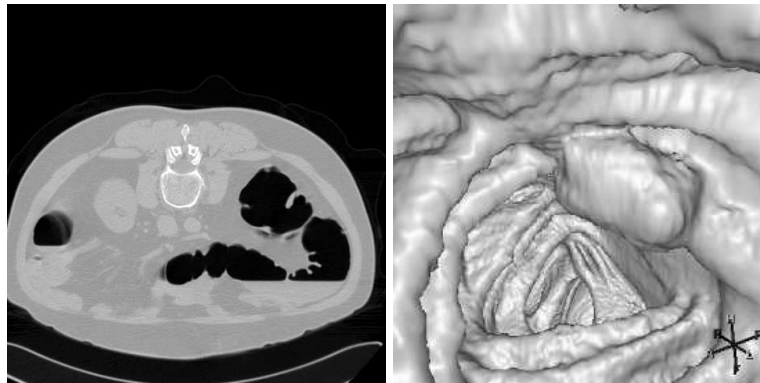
Grey image slice through a 3D volume obtained with CT Colonography (left). Isosurface rendering at -750 HU of the colon (right).
